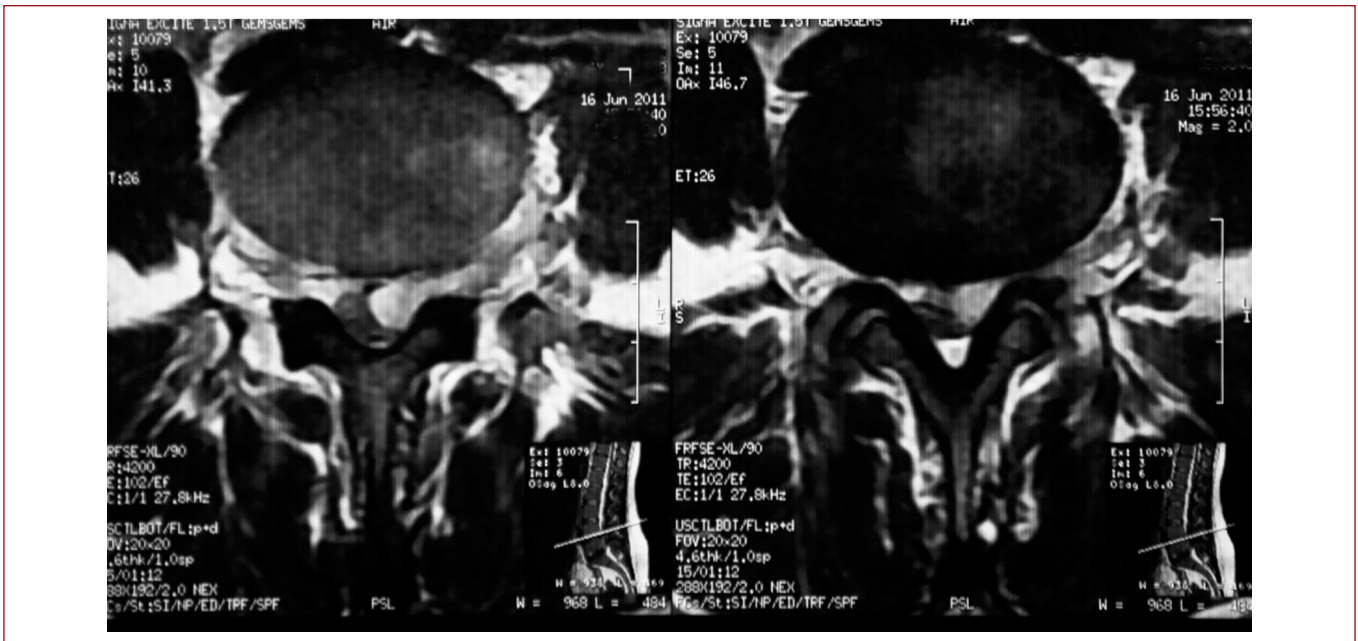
Axial MRI shows a mass filling the left-sided L4–5 foramen.
